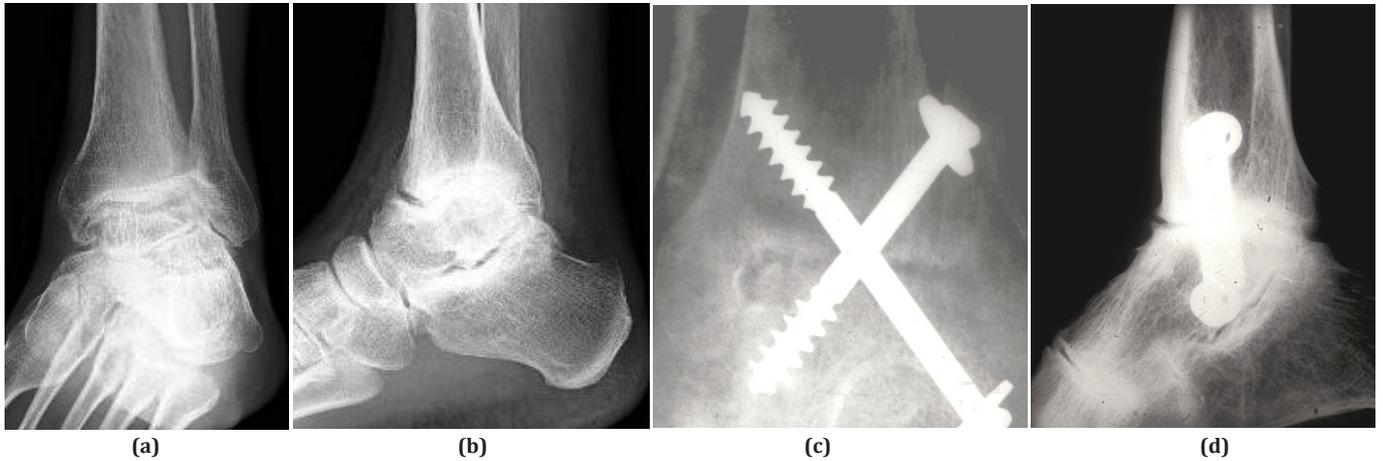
a-d. Tibiotalar arthrodesis performed with 2 crossed screws in very painful joint degeneration of the left ankle in an adult hemophilic patient. The result was satisfactory: (a) preoperative anteroposterior radiograph; (b) preoperative lateral image; (c) anteroposterior radiograph 3 months after arthrodesis; (d) lateral image 3 months after surgery.
